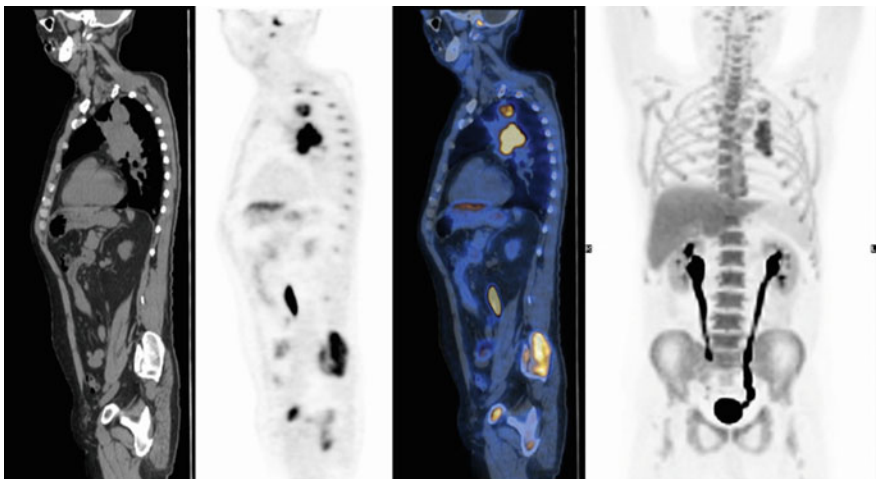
MIP image of ^{18}F -FLT PET/CT (right-sided panel of the figure), with sagittal images of a patient with NSCLC of the left upper lobe associated to large hilar adenopathies. Note the diffusely increased uptake of the tracer in the bone marrow, as physiological distribution
